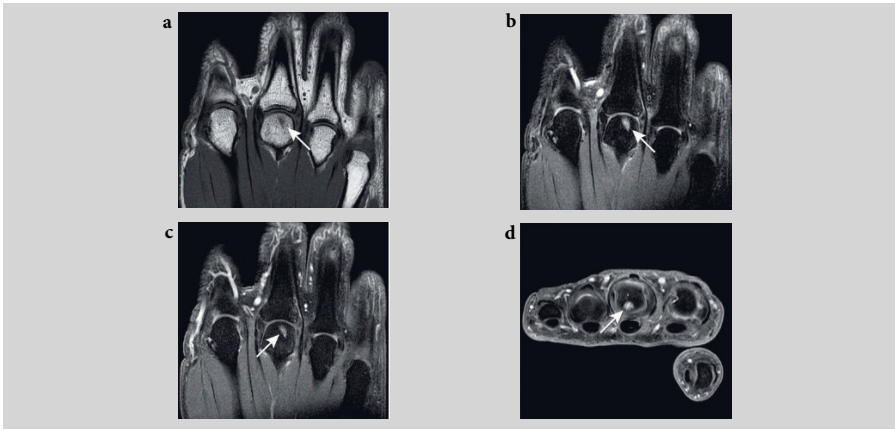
Magnetic resonance images (MRIs) of the right metacarpophalangeal joints in a patient with unclassified arthritis. Focal area in the head of metacarpal 3 of low signal intensity on T1 TSE (a), high on T2 TSE fat saturation (fatsat) (b), enhancing after gadolinium on T1 TSE fat sat (c, d). On the axial images, the volar subchondral location is appreciated, a cortical defect is not seen (however cannot be excluded). This finding is aspecific and can be based on a synovial cyst of no clinical importance or aspecific intraosseous edema. Its location, not at the level of ligamentous insertion, is less convincing for an erosion. There is no pathologic enhancing synovium. Follow-up in time may be of additional value.
